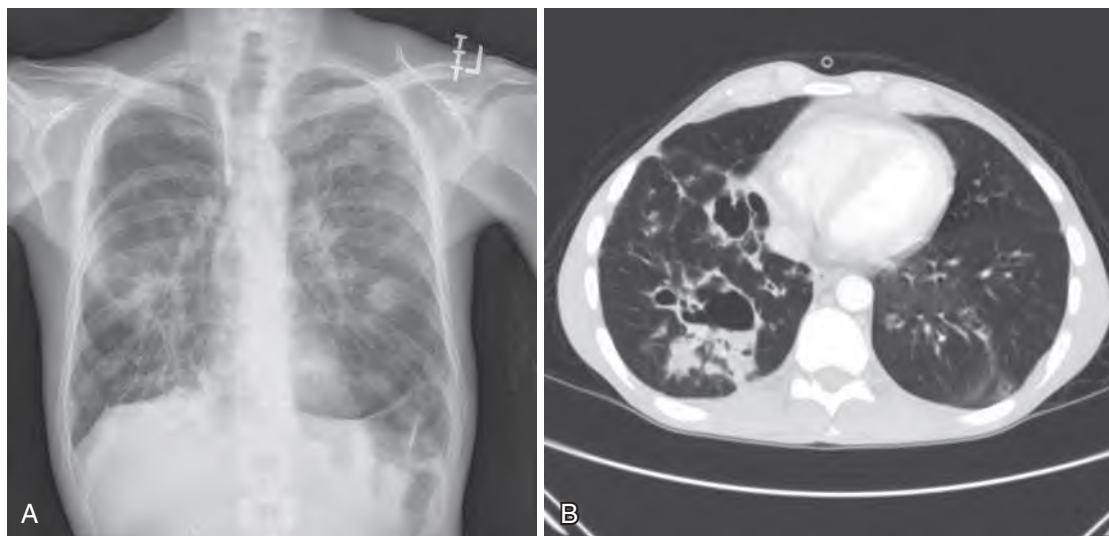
(A) This 68-year-old white male with acute myelogenous leukemia had recently undergone myeloablative chemotherapy as part of his induction course. He experienced profound and prolonged neutropenia, and on the 21st day of fever and neutropenia he complained of cough and scant hemoptysis. A routine chest radiograph revealed multiple nodular lesions in both lungs, some with cavitation. A diagnosis of invasive aspergillosis was suspected, and a serum and bronchoalveolar lavage galactomannan were both positive (1.1 and 2.3, respectively), thus establishing a diagnosis of probable invasive pulmonary aspergillosis. (B) A computed tomography scan from the same patient reveals multiple cavitary lesions from the right lung consistent with invasive pulmonary aspergillosis. Extensive cavitation such as shown is not usually observed until neutropenia has improved or immunosuppression has lessened.
